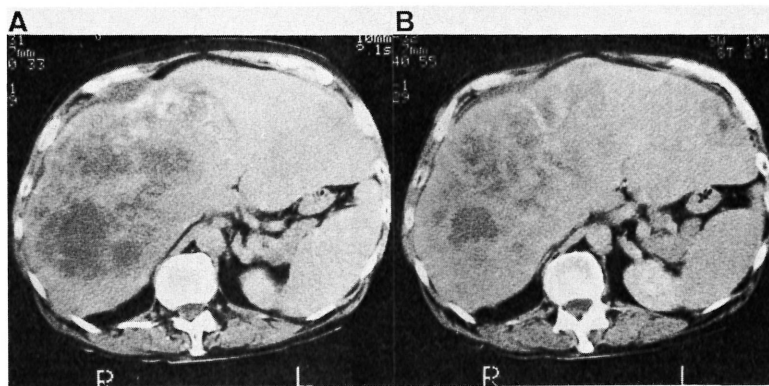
CT scans of patient 1 with multiple hepatic metastases before treatment (A) and 1 month after treatment (B).
